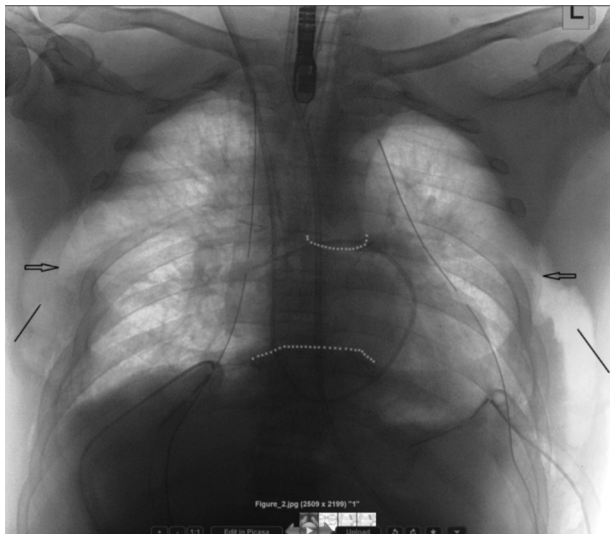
Radiography of Open Chest With Lungs Bulging Out
